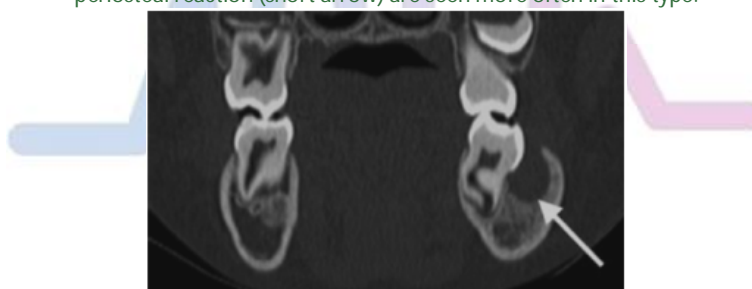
Mandibular infected buccal cyst (buccal bifurcation cyst). Coronal reformatted CT image shows a cyst (arrow) buccal to the roots of the lower right second molar tooth, resulting in characteristic tilting of this tooth.
